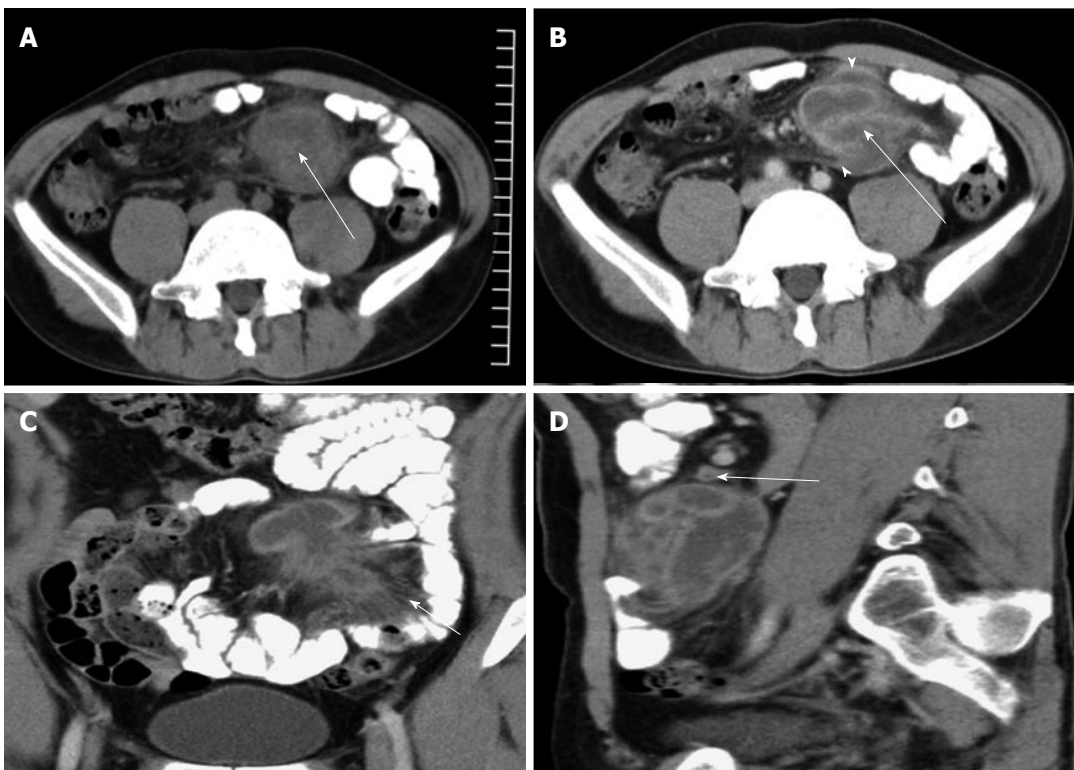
Tuberculous abscess in the mesentery. A: Axial CT image showed a low density abscess measuring 4.5 cm × 6.2 cm in the small bowel mesentery (arrow); B: Axial CT image (venous phase) showing a low density abscess with enhancement of the wall and septa (arrow). Adjacent parietal peritoneum was thickened with heterogeneous enhancement (arrowhead); C: Coronal CT image showed that the abscess was irregular. The density of the mesentery was increasing. Crowded mesenteric vascular bundles and thickened fiber strands were seen (arrow); D: Sagittal CT image showed a low density abscess with rim enhancement and slightly enlarged lymph nodes (arrow). CT: Computed tomography.
